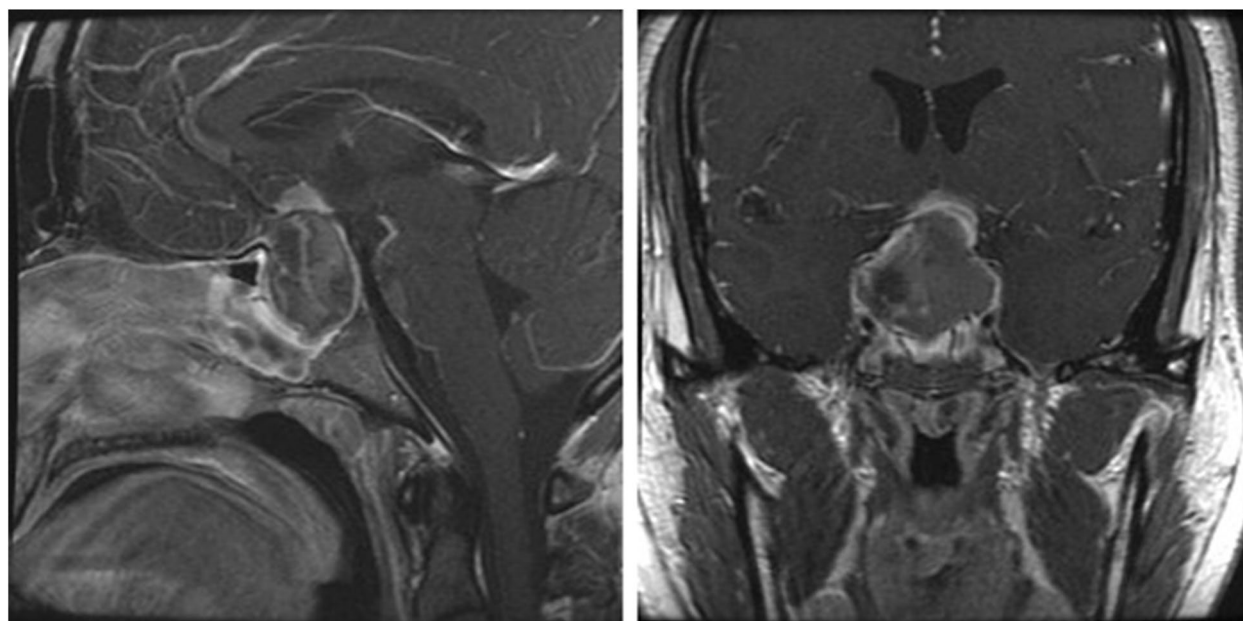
Sagittal and coronal T1-weighted MRI showing evidence of pituitary apoplexy. A pituitary tumor fills the sella and extends into the suprasellar space, where it compresses the optic chiasm and the pituitary gland, causing sudden severe headache, loss of vision, and low levels of anterior pituitary hormones causing asthenia. A subarachnoid component of bleeding is seen at the upper pole of this tumor, as occasionally in pituitary apoplexy blood leaks into the subarachnoid space and intensifies the patient's symptoms
